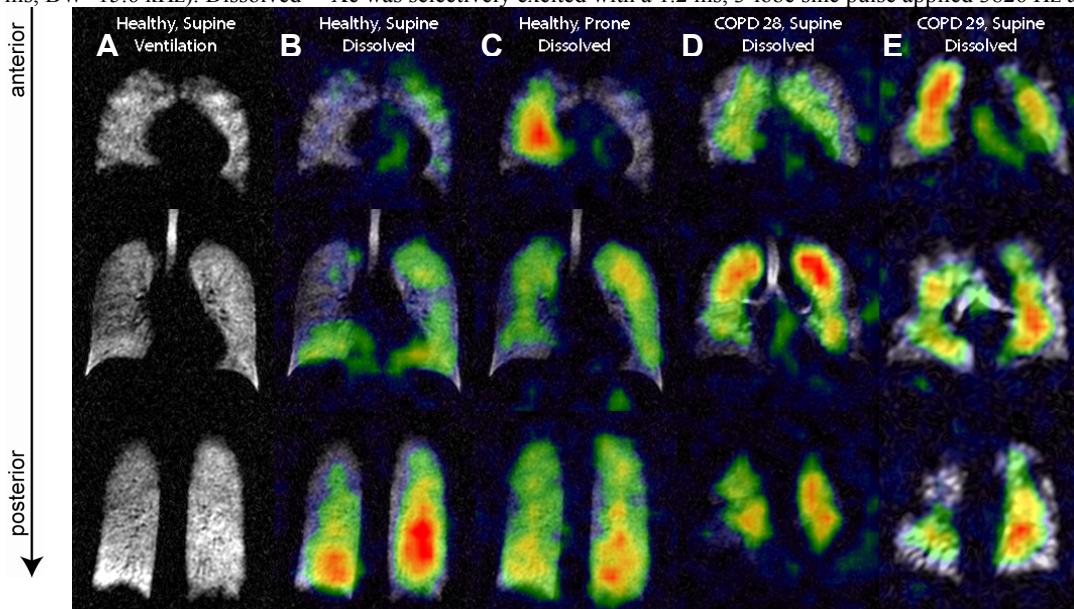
HP ^{129}Xe MR images. (A) Representative slices from the ventilation image of a healthy subject. (B) Dissolved ^{129}Xe image (color) overlaid on (A). Image was acquired after the subject had been supine for 1 hr. Despite homogeneous ventilation, the dissolved ^{129}Xe image displays a heterogeneous signal intensity pattern consistent with a gravity-dependent distribution of capillary blood volume. (C) Same subject as in (B) imaged 10 min after moving to the prone position. Now the gravitationally dependent (anterior) slices display increased signal intensity. (D) Dissolved ^{129}Xe image from a supine COPD patient. The signal intensity pattern is also heterogeneous, but displays less gravitational dependence than is seen in (B) and (C). (E) Dissolved image from a second COPD patient. Again a heterogeneous, but less gravitationally dependent, pattern is observed.
